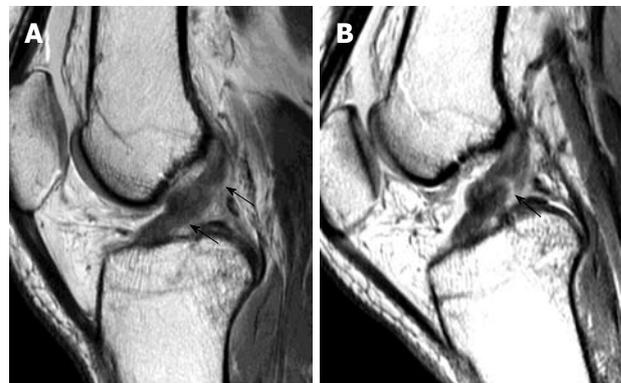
Magnetic resonance knee in partial flexion. Volunteer, 31-year-old man with no history of injury and clinical instability. Sagittal intermediate-weighted magnetic resonance image in full extension. A: And 30 degree of knee flexion; B: Demonstrates the usefulness of knee flexion. When the knee is extended, sagittal image shows features suspicious of an anterior cruciate ligament (ACL) tear. When the knee is flexed, a gap (black arrow) is clearly present confirming the presence of an ACL tear.
